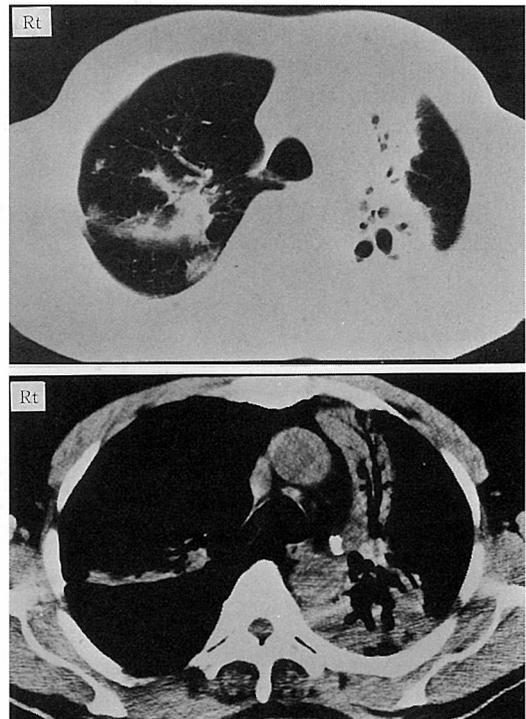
Chest CT showing mass-like consolidation with shaggy borders and air bronchogram in the left lung. Also, ill defined segmental consolidation was seen in the right upper lobe, with several small consolidations surrounding the lesion.
